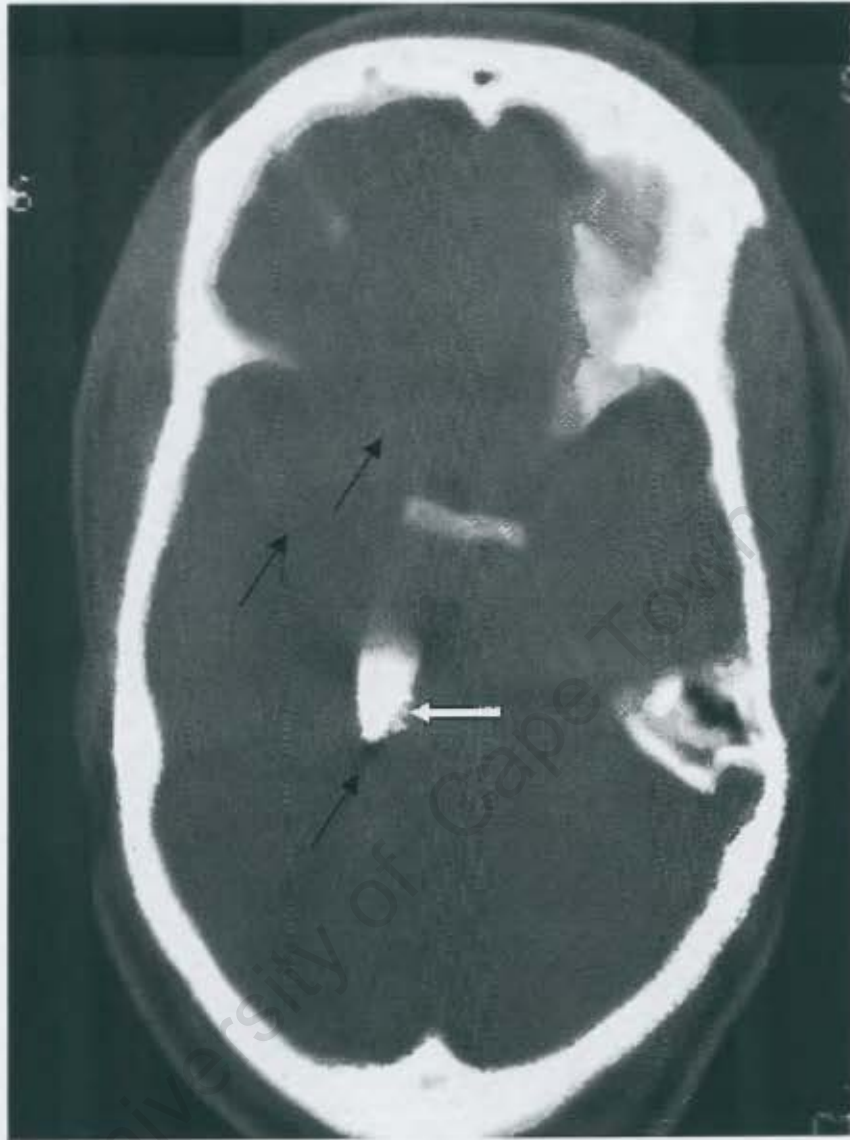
(B): Case 31. Uncontrasted axial CT of the brain (bone windows) demonstrating the metal streak artifact (single arrows) surrounding the tip of the retained knife (white arrow).
